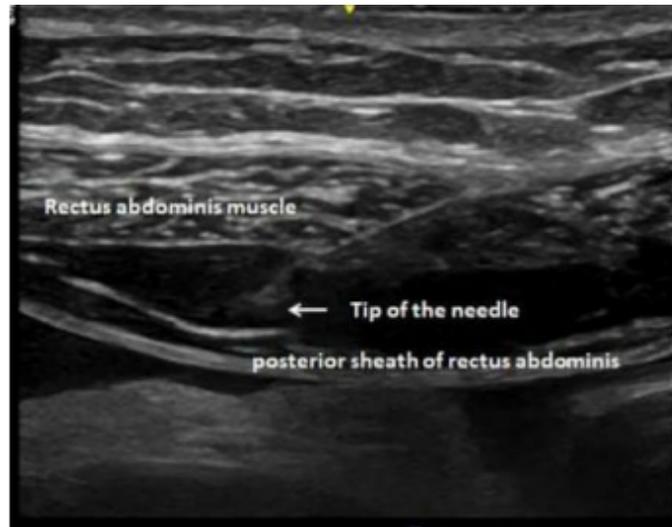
Ultrasound Guided Rectus Sheath Block
